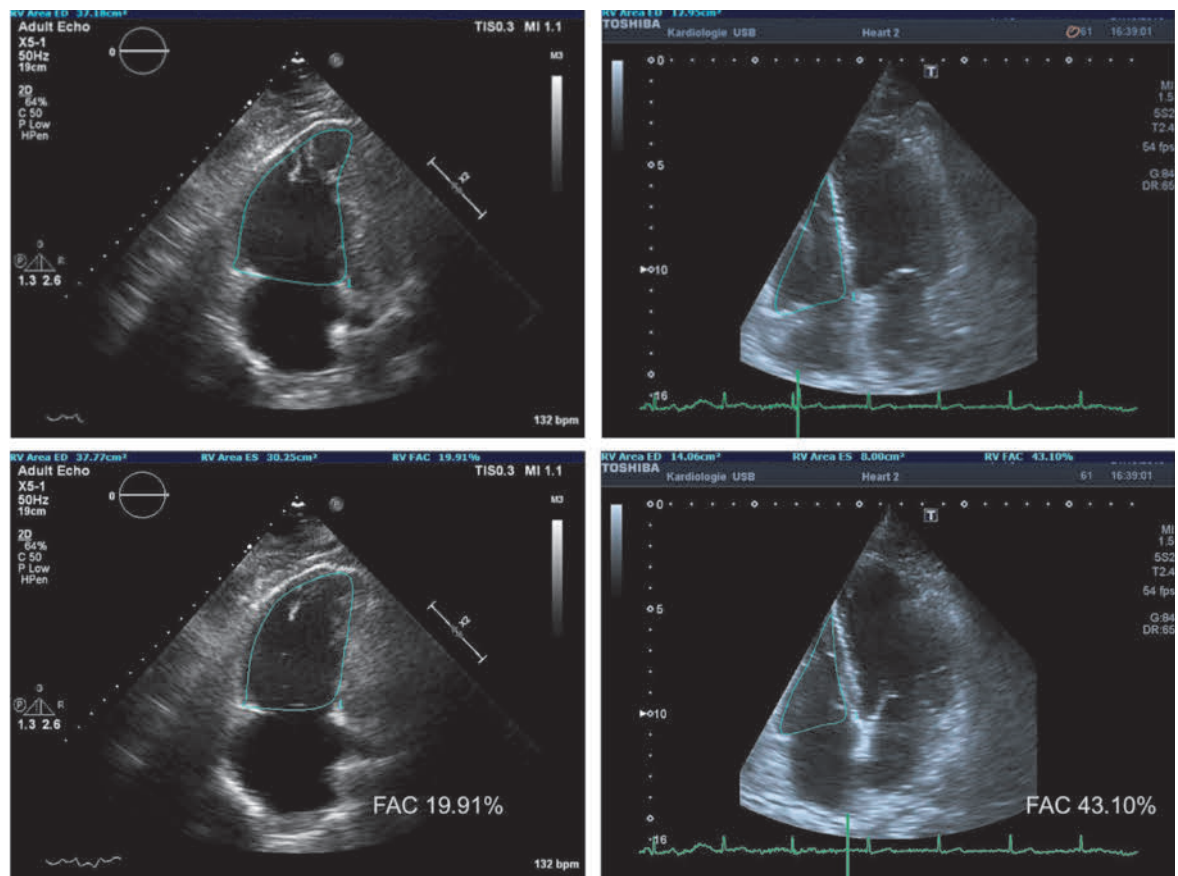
Examples of right ventricular fractional area change (FAC). The endocardial border is traced in apical 4-chamber (A4C) at end-diastole (top) and end-systole (bottom). Trabeculation, tricuspid leaflets, and chords are included in the chamber. Left: optimized view for the right ventricular chamber (RV), FAC 19.9%, dilated RV. Right: Normal subject, FAC 43.10%.
